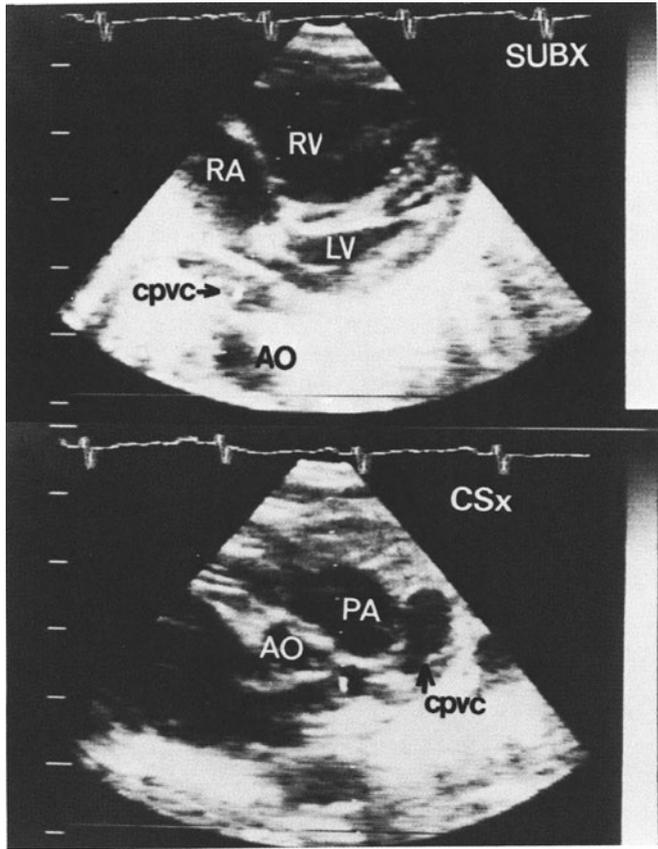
The 2-D of TAPVR to the innominate vein (AO, aorta; PA, pulmonary artery; CSX, parasternal cross-section. Other abbreviations as in Figure 1).
